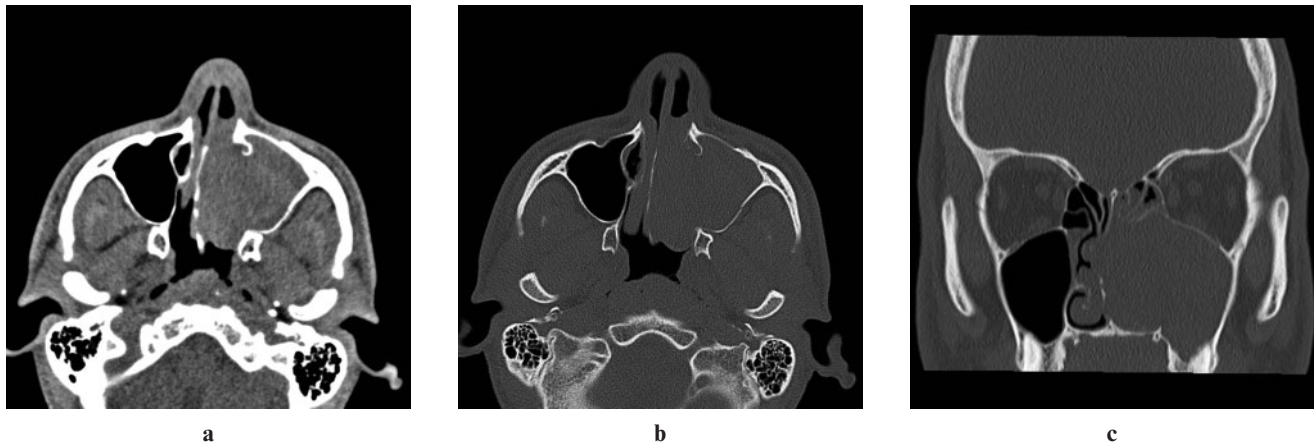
CT images without contrast, (a) axial soft-tissue window, (b) bone window and (c) coronal bone window show a large soft-tissue mass occupying the left maxillary sinus and extending into the nasal cavity. The mass is associated with remodelling of the posterior wall of the left maxillary sinus, inferior orbital wall and nasal septum as well as erosion of the medial maxillary sinus wall. On the soft-tissue view (a), the lesion contains zones of high density
